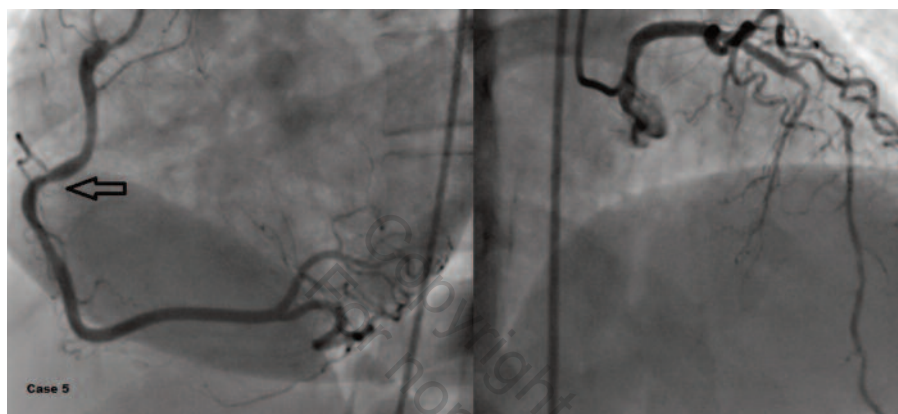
A 59-year-old female was admitted to our hospital with typical chest pain for 1 month. She had hypertension for 3 years and a 20 pack-year smoking history. Before coronary angiography, myocardial perfusion scintigraphy examination revealed reversible ischemia at the mid and apical levels of the anterior left ventricular wall. Coronary angiography demonstrated a subtotally occluded mid LAD lesion and an intermediate stenosis of proximal RCA (arrow) giving poor collateral circulation to the LAD. Initial and final FFR values were 0.84 and 0.88, respectively.
